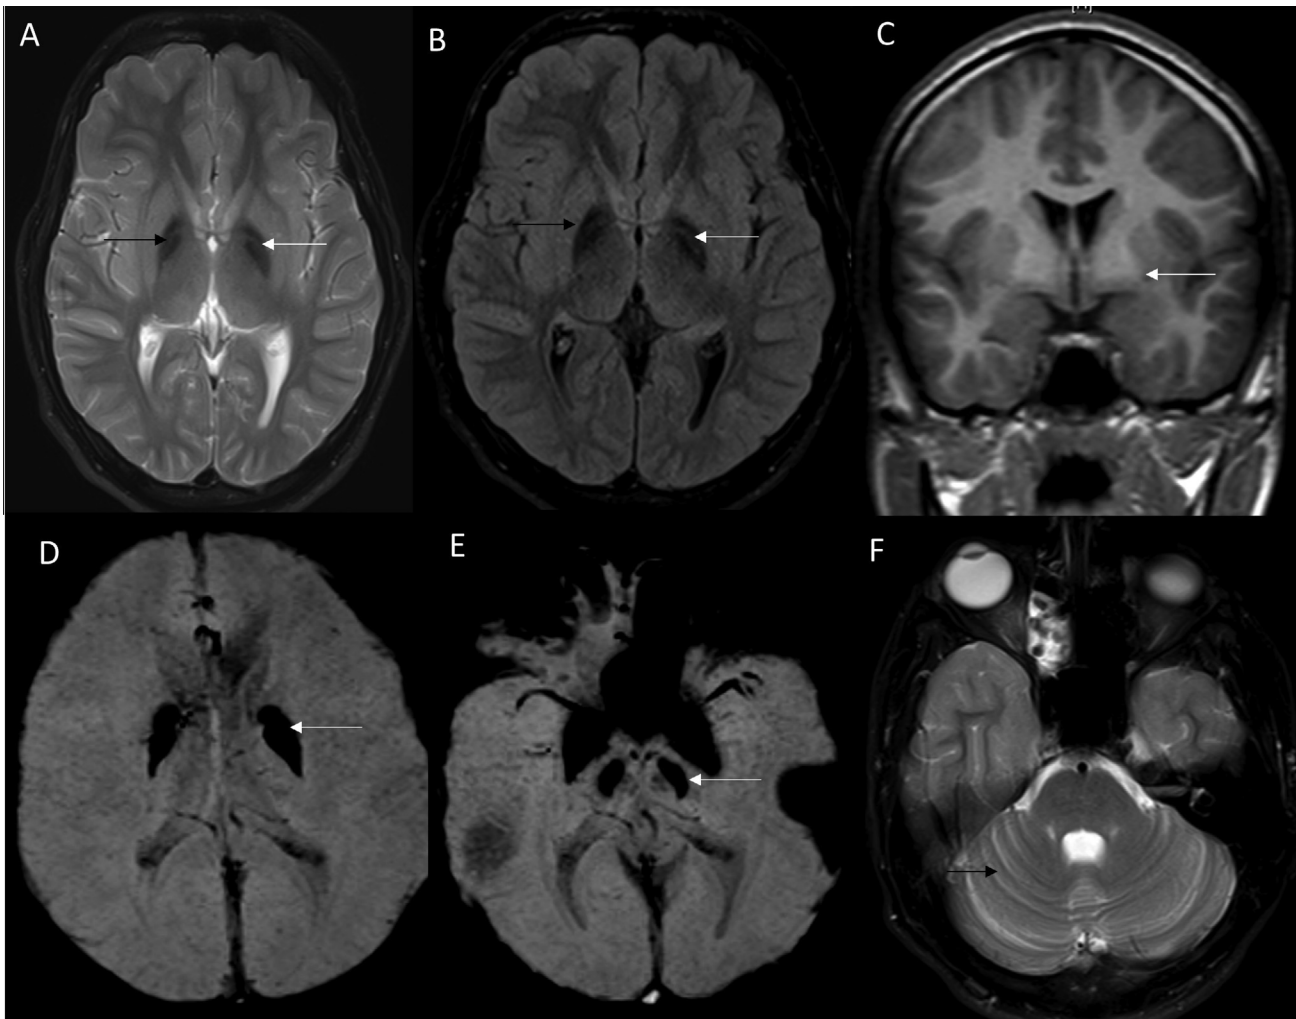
MRI brain T2 axial and FLAIR (A and B) imaging of index case shows bilateral symmetric hypo intensity of globi pallidi (black arrows), faint hyper intensity is seen along the medial medullary lamina (white arrows). T1 coronal image (C) shows faint hyper intensity of globi pallidi. Susceptibility Weighted Imaging (SWI) shows hypointensity and blooming of globus pallidus and substantia nigra (white arrows in D and E, respectively). T2 axial image at cerebellar level (F) shows mild volume loss.
